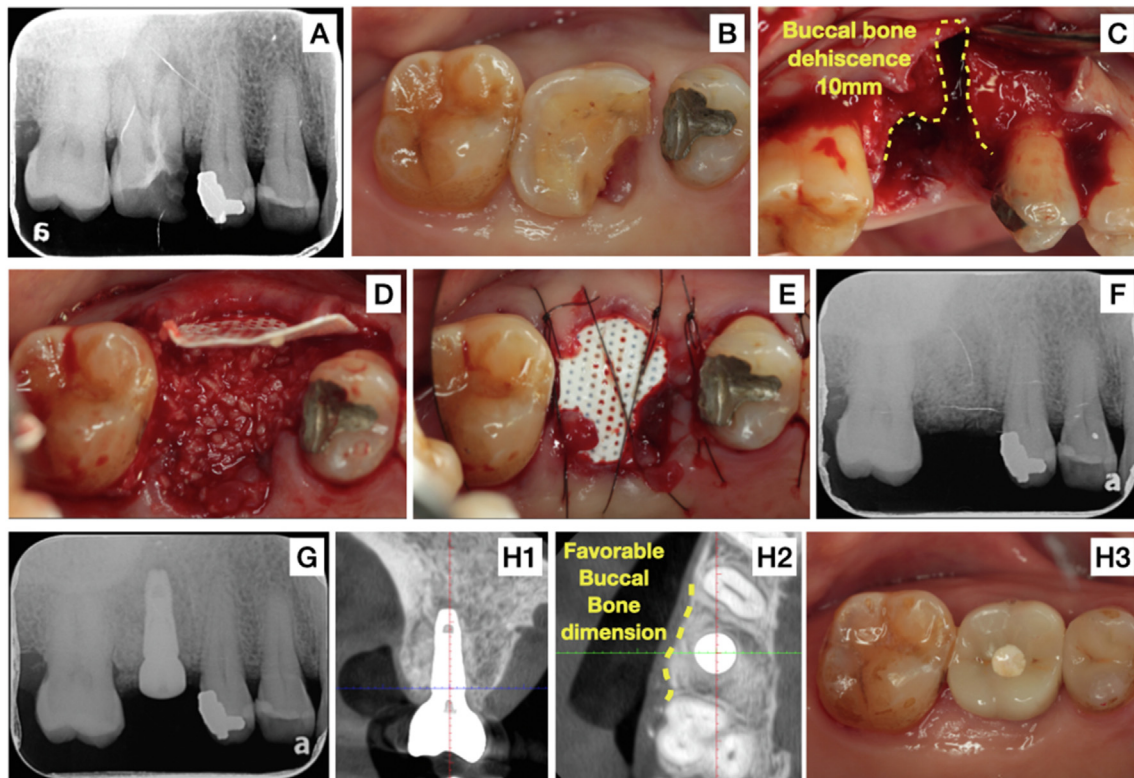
Clinical photographs and radiographs of this case: (A and B) Tooth 16 crown-root fracture with apical radiolucency. (C) After tooth 16 extraction and flap reflection, buccal dehiscence towards apex was noted. (D) Non-resorbable d-PTFE membrane (12 × 24mm Cytoplast™) and freeze-dried allogenic bone substitute (0.5 cc 0.5–1.0 mm Maxxeus) filling the extraction socket. (E) Wound sutured with 5–0 Nylon stitches. (crisscross and interrupted) (F) Radiograph taken immediately after extraction and alveolar ridge preservation. (G) Radiograph taken after implant placement at nine-month post-extraction without the need of additional bone augmentation. (H) Cone Beam Computed Tomography images and clinical photograph after final crown delivery, showing stable implant fixture with favorable buccal bone thickness.
